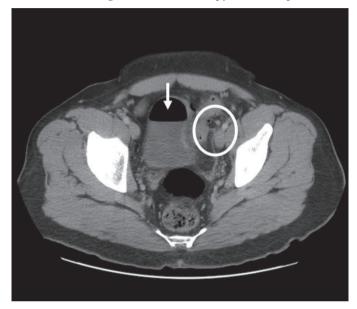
Axial views of CT scan of a patient with recurrent diverticulitis and colovesical fistula. Air fluid level is seen inside the bladder [arrow]. An adjacent inflamed sigmoid colon with diverticulae is noted [circle] *CT: Computed tomography*
